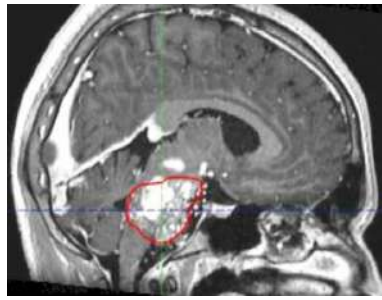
A. T1 axial MRI shows a Hypointense pituitary adenoma lesion with CTV and PTV contours made for SRS planning.
